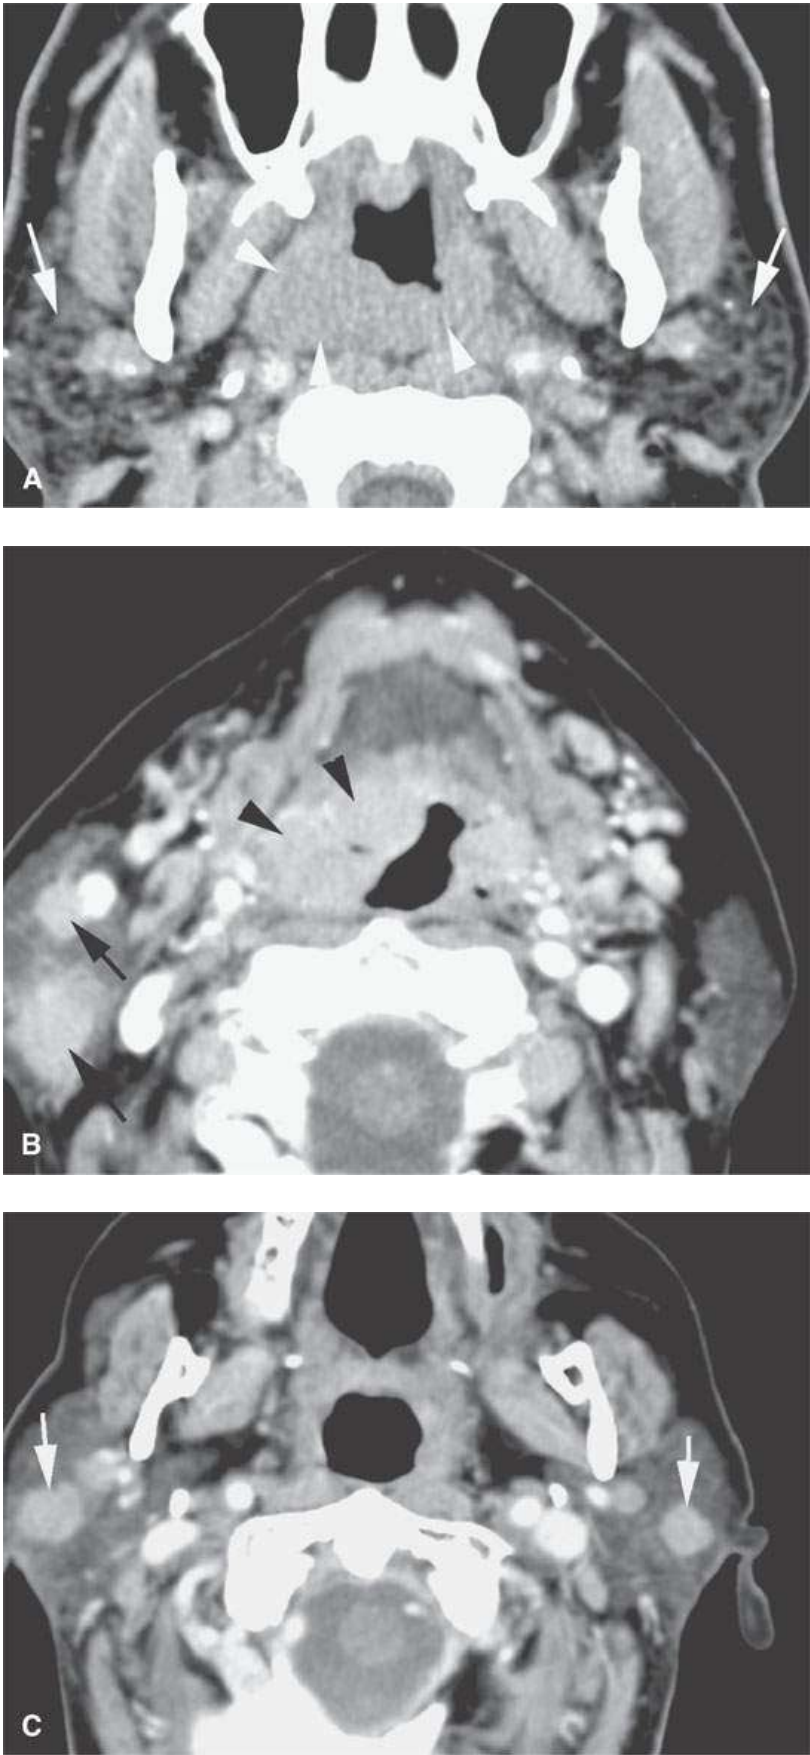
Contrast-enhanced computed tomography (CT) of a patient with long-standing Sjögren disease (*arrows in A*) with a secondary lymphoma. The patient developed some suspicious adenopathy clinically leading to this CT. A–C: CT showed an infiltrating mass in the nasopharynx (*arrowheads in A*) and oropharynx (B) in the lymphoid tissue of the Waldeyer ring (*arrowheads*). Enlargement of parotid nodes (*arrowheads*) was also present (*arrows in B and C*). The findings prompted biopsy that confirmed lymphoma.
